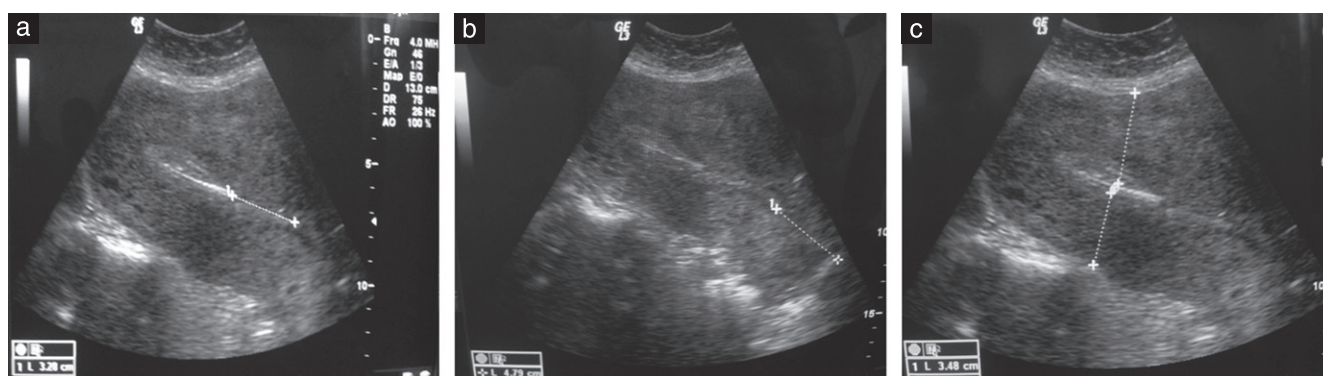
Transabdominal ultrasound images in a woman with an intrauterine contraceptive device (IUD) inserted immediately after vaginal birth, showing: (a) distance from lower end of IUD to internal os, (b) cervical length and (c) distances from IUD to anterior and posterior walls of uterus.
